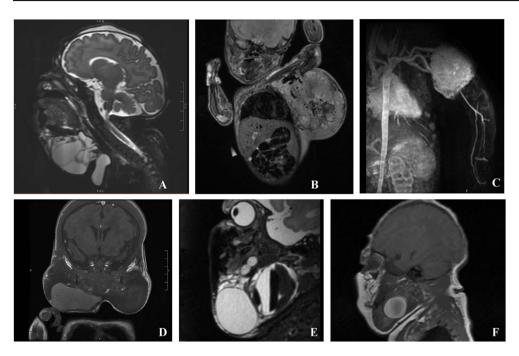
A-F. Representative radiographic images of vascular anomalies from each patient.
